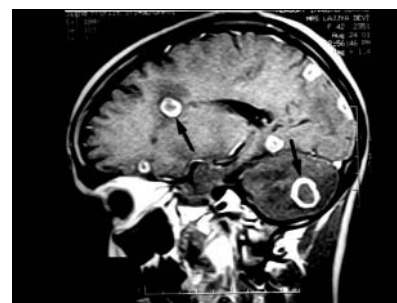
Cranial MRI, post-contrast sagittal section showing ring enhancing lesions (arrows) in the cerebral hemispheres and cerebellum.
